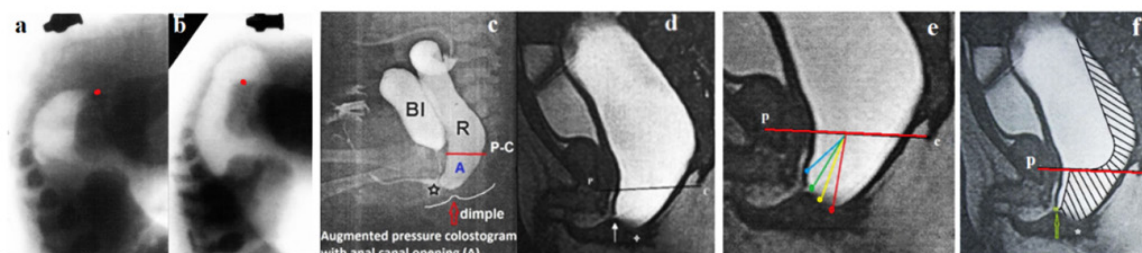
Radiologic studies in males with ARM without visible fistulas. (a). On the radiograph of a newborn 30 hours after birth, the gas reaches the caudal part of the ischium (red dot), (b). In the same patient, during abdominal compression, the gas penetrated the anal canal and approached the contrast marker glued to the anal dimple. (c, d) Augmented-pressure distal colostograms: (c-X-ray) and (d-MRI). In both cases, under the high pressure, the anal canal (caudal to P-C line - red) opened, and its caudal wall approached the anal dimple. (e). Scheme of anal ectopy variants at high pressure in the rectum. The anal canal is wide open: red indicates the normal position of the anus (congenital anal stenosis); yellow - perineal fistula; green - bulbar fistula; blue - prostatic fistula. (f). Scheme at low rectal pressure. The rectum is narrow. The anal canal is in a contracted state.
